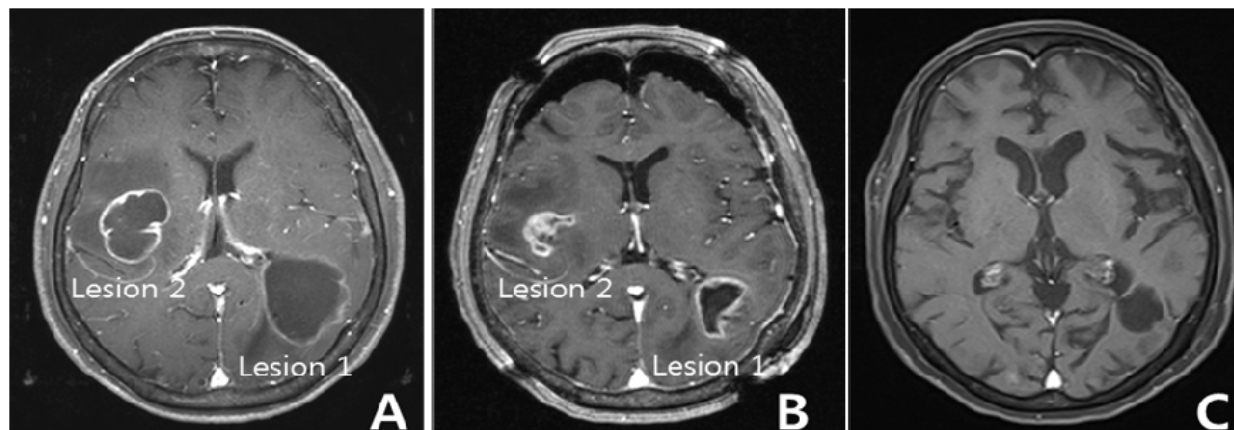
Axial gadolinium-enhanced T1-weighted MR image of a 70-year-old woman with two large cystic brain metastases developing from breast cancer. A : Before aspiration : initial cyst volume of lesion 1, 34.7 cc; of lesion 2, 11.0 cc. B : After cyst aspiration : cyst volume of lesion 1, 8.0 cc ; of lesion 2, 0.9 cc. The prescription dose was 23 Gy for lesion 1 and 25 Gy for lesion 2. C : Image obtained 12 months postradiosurgery showing no definite enhancing tumors.
